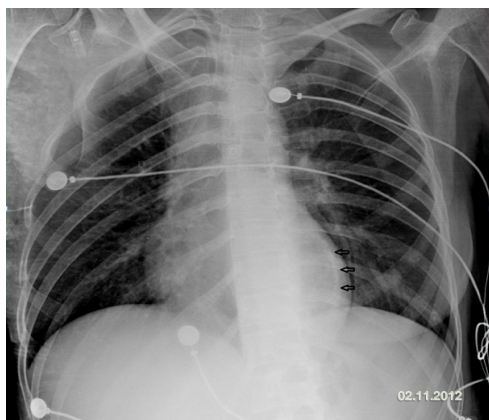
Anteroposterior radiograph performed on day 24 after the ICU admission demonstrating a vague curvilinear calcification along the left ventricular wall (arrows).
